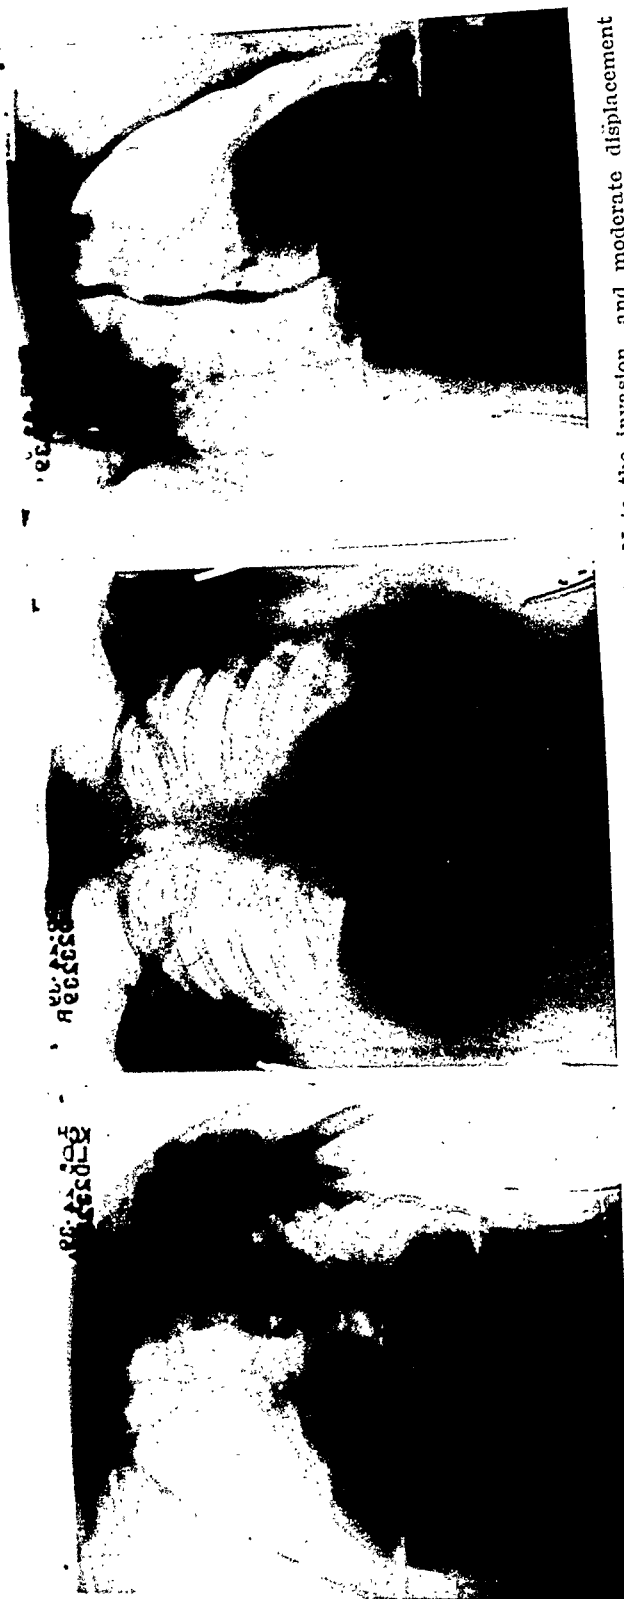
Roentgenograms of Patient A. G., Case 9. Patient twenty-six weeks pregnant. Note the invasion, and moderate displacement backwards, of the esophagus in right anterior oblique view.
